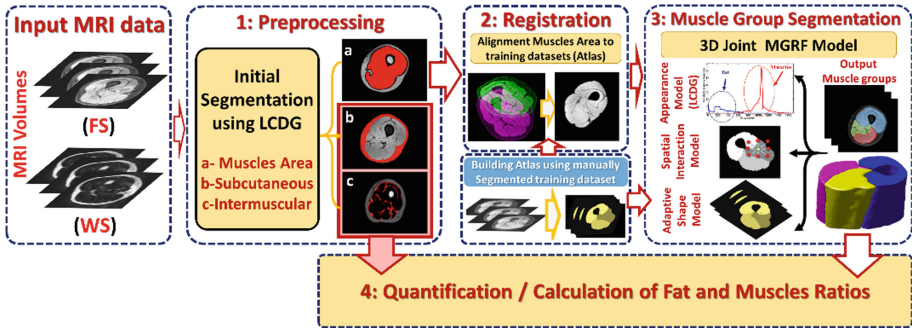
The proposed framework for muscles/fat analysis based on MRI data.
